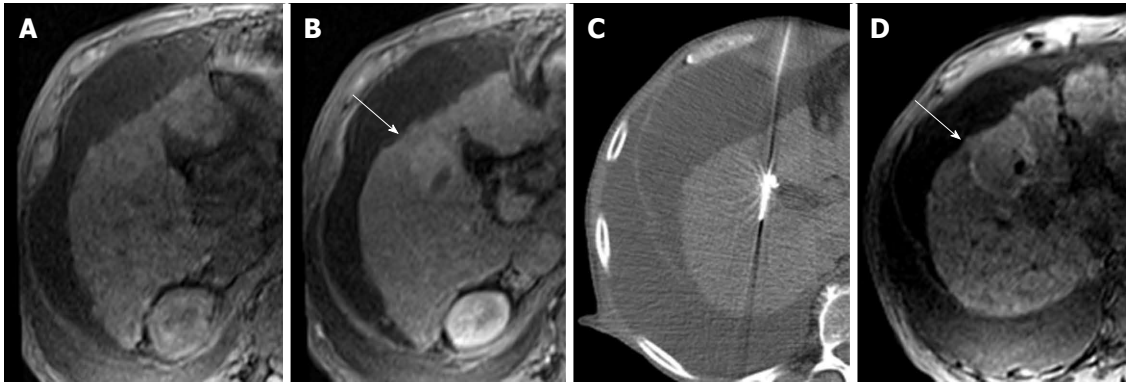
Treatment-related signal alterations on T1-weighted images. A 59-year-old man with HCV cirrhosis and a segment V LI-RADS 5B lesion measuring up to 3.6 cm. Fat-saturated T1-weighted precontrast (A) and arterial-phase (B) images demonstrate a 3.6 cm enhancing focus of viable tumor (B, arrow) within an area previously treated with TACE. Mass could not be visualized upon selective angiography so repeat TACE was not performed. Non-contrast CT from a radiofrequency ablation procedure (C) demonstrates an electrode positioned within the tumor. One month later a fat-saturated T1-weighted precontrast image (D) demonstrates peripheral high signal related to hemorrhage from coagulative necrosis (D, arrow). LI-RADS: Liver imaging reporting and data system; TACE: Transarterial chemoembolization; HCV: Hepatitis C virus.
